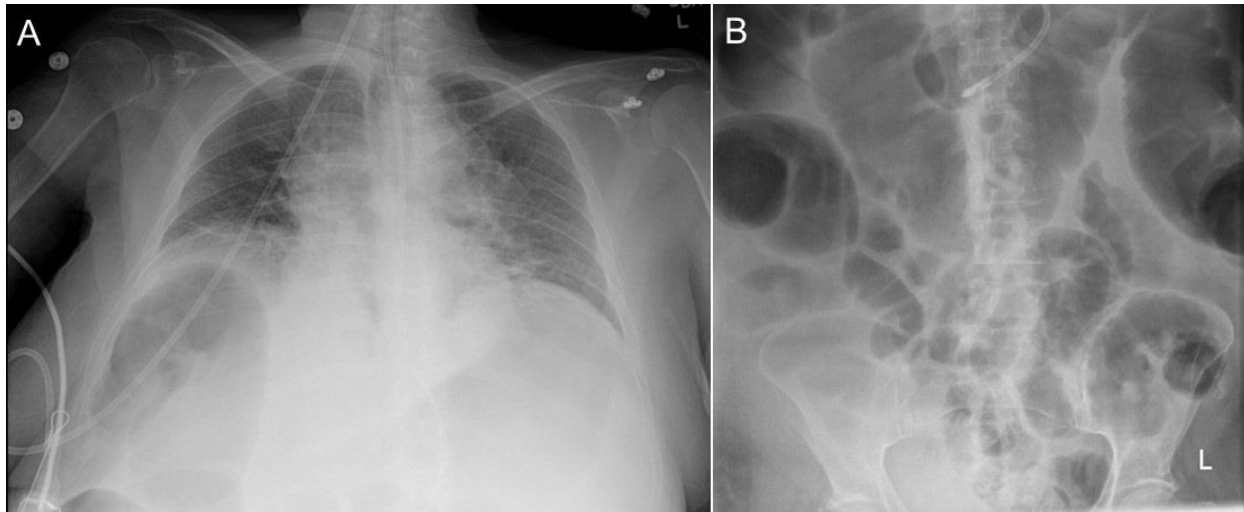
Admission chest (A) and abdominal (B) radiographs.
